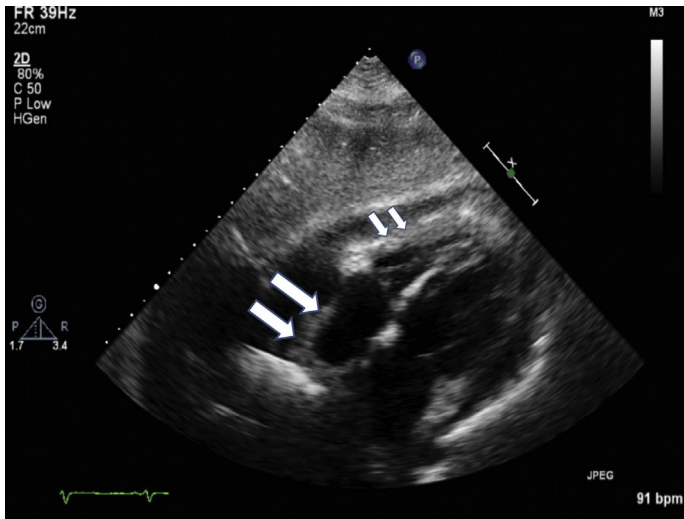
Two-dimensional echocardiographic image of pericardial tamponade showing diastolic right atrial (*large arrows*) and right ventricular indentation (*small arrows*) in the subcostal window.
